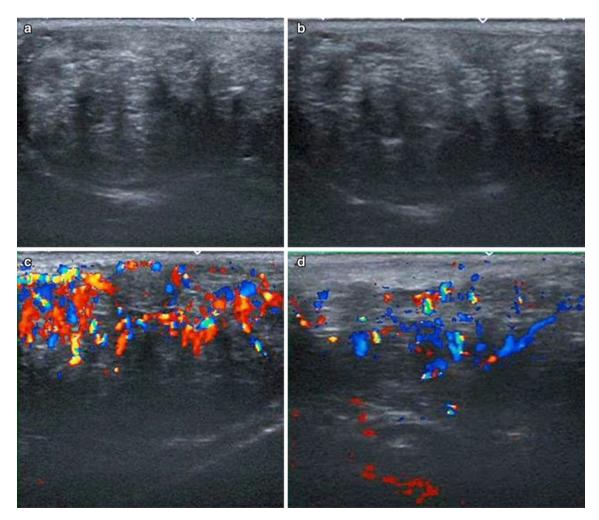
Testicular sonography in a patient with decompensated androgenital syndrome. The testes are mildly enlarged with widespread alterations of their echostructure (a, b), which is
